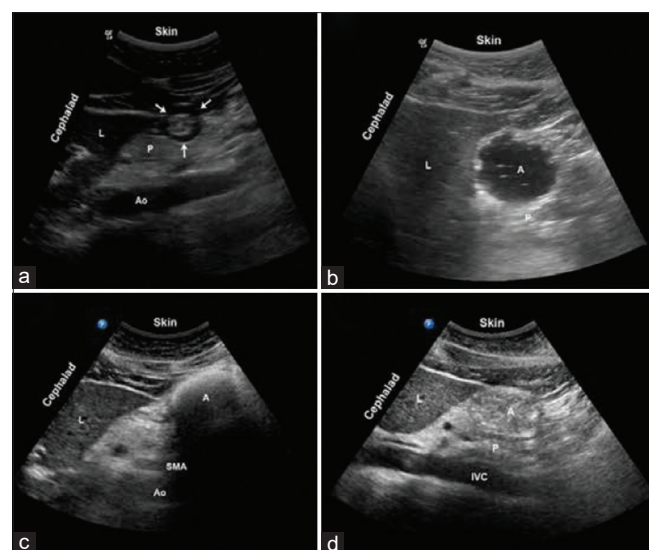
(a-d) Gastric point-of-care ultrasound images^[25]
